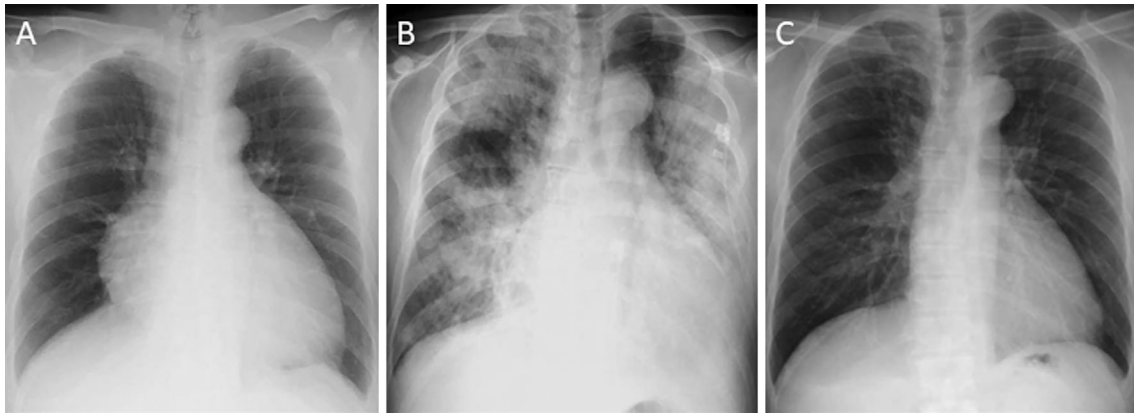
Chest X-ray findings on (A) days 1, (B) 12 and (C) 21.
